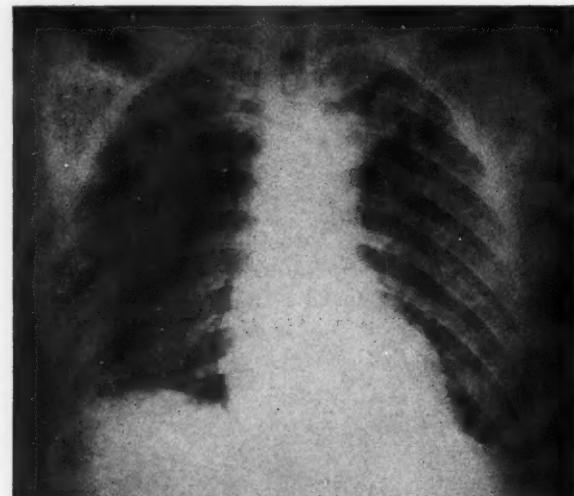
Chest roentgenogram of Case II, J. V., three weeks after onset of symptoms.
